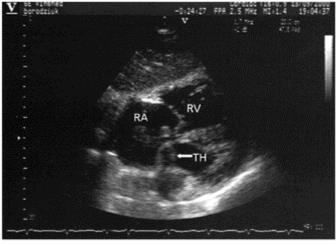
(A) Right atrium (RA) mobile thrombus (RAMT) (arrow) in diastole prolapsing into the right ventricle (RV). (B) Subcostal approach detects penetration of thrombus (TH) via patent foramen ovale into the left atrium. (Reproduced from Echocardiography. Hoffman P, Kasprzak JD (eds). Gdansk: ViaMedica, 2004.)
